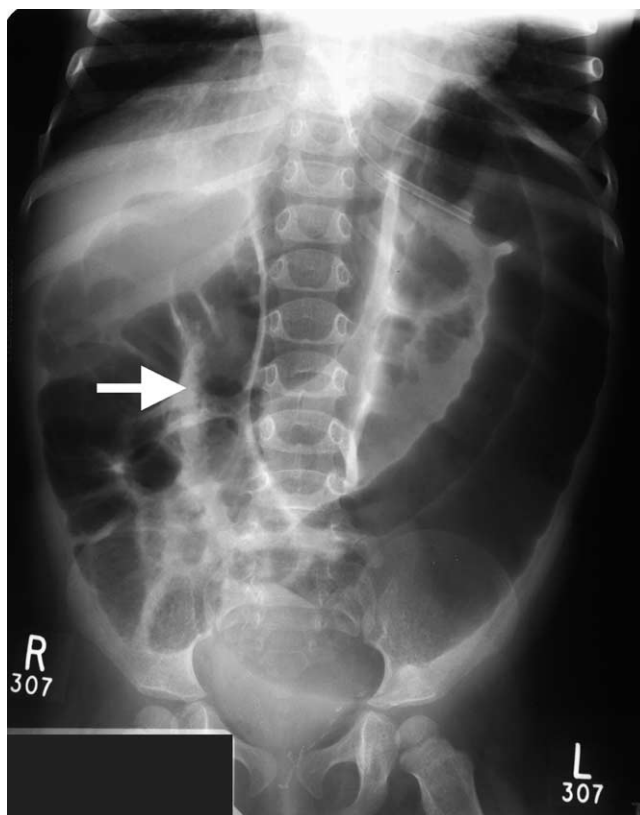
Abdominal radiograph of a 3-year-old girl with HEC showing gaseous distension of the large bowel. Toxic megacolon is seen with evidence of mucosal thickening (arrow).
